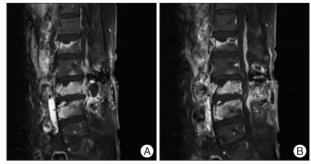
Contrast enhanced lumbar spine magnetic resonance image. Right epidural abscesses occupying the right lateral canal and right laminectomy site at the level of the L2 to L4 vertebral bodies (A). Multiple areas with irregular enhancing high signals in the posterior epidural space of the L2 to L3 spines suggesting an inflammatory lesion such as osteomyelitis (B).
